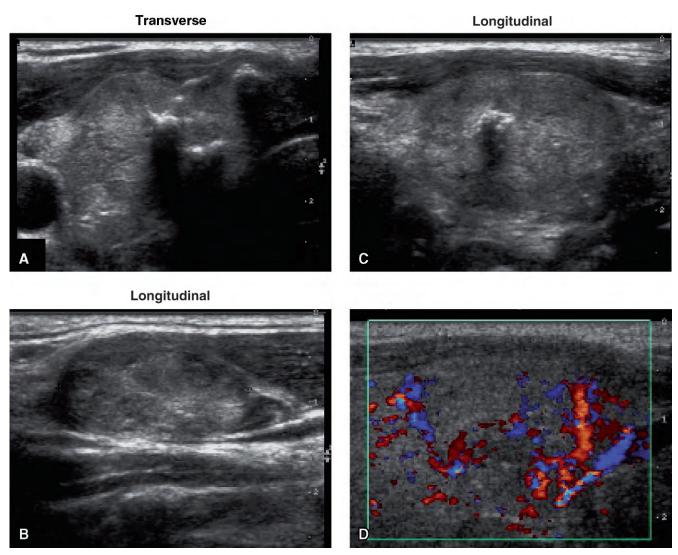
Ultrasound of papillary thyroid carcinoma in the right lobe. A, Transverse. B, Longitudinal showing metastasis. C, Longitudinal. D, Color Doppler, longitudinal.
